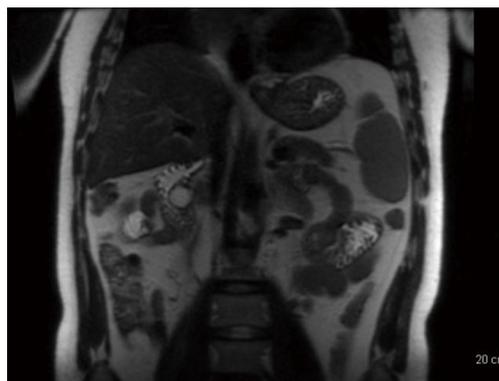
A cystic lesion in the area of the distal common bile duct, bulging into the duodenal lumen is seen in the magnetic resonance imaging.
